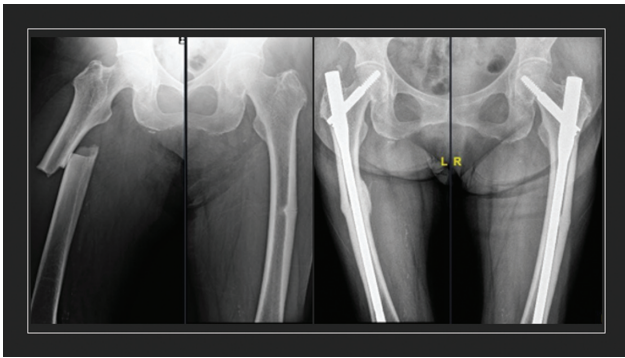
(A) Preoperative radiographic image of an atypical bilateral fracture. (B) Radiographic image 7 months after surgery.
